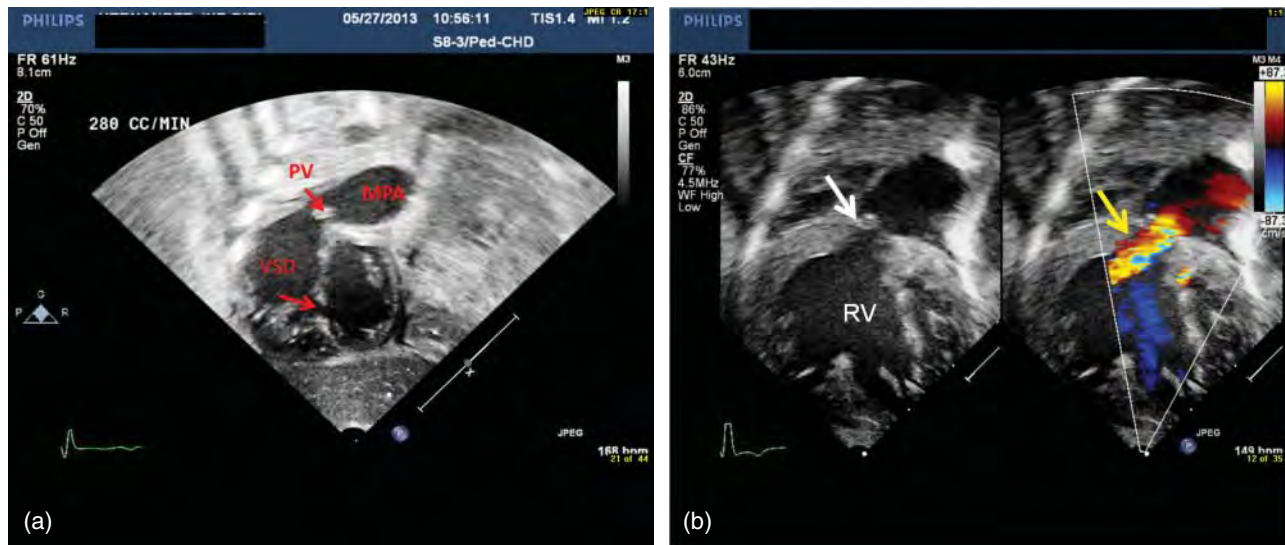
Postnatal transthoracic echocardiogram images of the same patient as in Figure 29.3. (a) The dysplastic pulmonary valve (PV) and dilated main pulmonary artery (MPA) can be seen as well as a muscular ventricular septal defect (VSD). Notice that transthoracic echocardiogram is performed while patient is on 280 mL/min ECMO flow (full support). (b) 2D and color images of a subcostal view showing significant pulmonary valve regurgitation (yellow arrow). Thickened, dysplastic pulmonary valve (white arrow) is well demonstrated. Notice also dilated, hypertrophied right ventricle (RV). (c) Subcostal 2D and color images demonstrate the dysplastic valve (PV) with poor coaptation (yellow asterisk) as well as a severely dilated main pulmonary artery (MPA).
